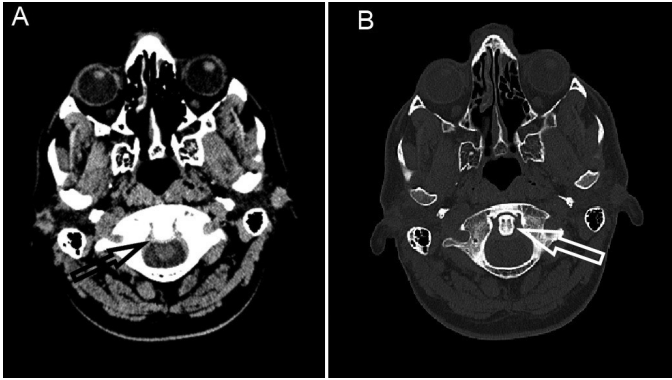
Cranial computed tomography images show (A) reduction of the anterior subarachnoid space with no compression of the medulla spinalis (black arrow) and (B) dens protrusion into the infratentorial region with compression (white arrow)
